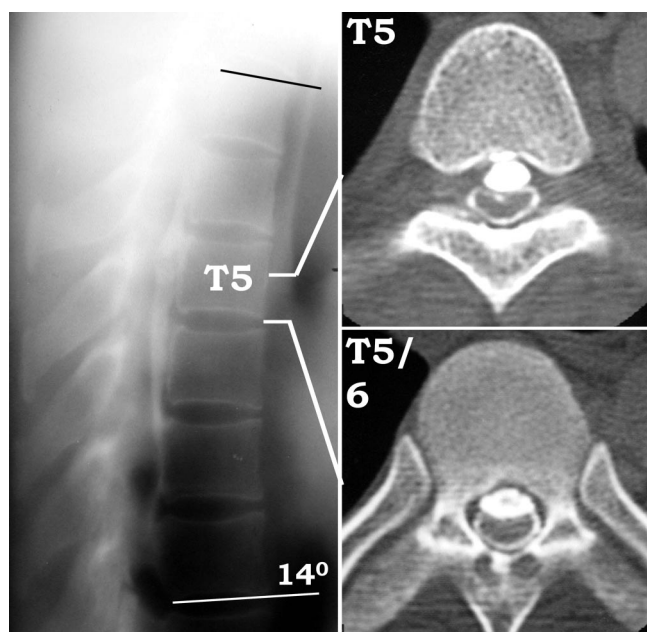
Preoperative radiographic images obtained in a 53-year-old man with thoracic myelopathy. A midsagittal tomogram at thoracic spine (left) shows a continuous type ossification of the posterior longitudinal ligament (OPLL) from T3 to T8. Thoracic kyphosis at T3–T8 is 14°. Axial views of computed tomography (CT) myelogram at T5 (right, upper) and T5–T6 (right, lower) indicate OPLL compressing the spinal cord anteriorly.
